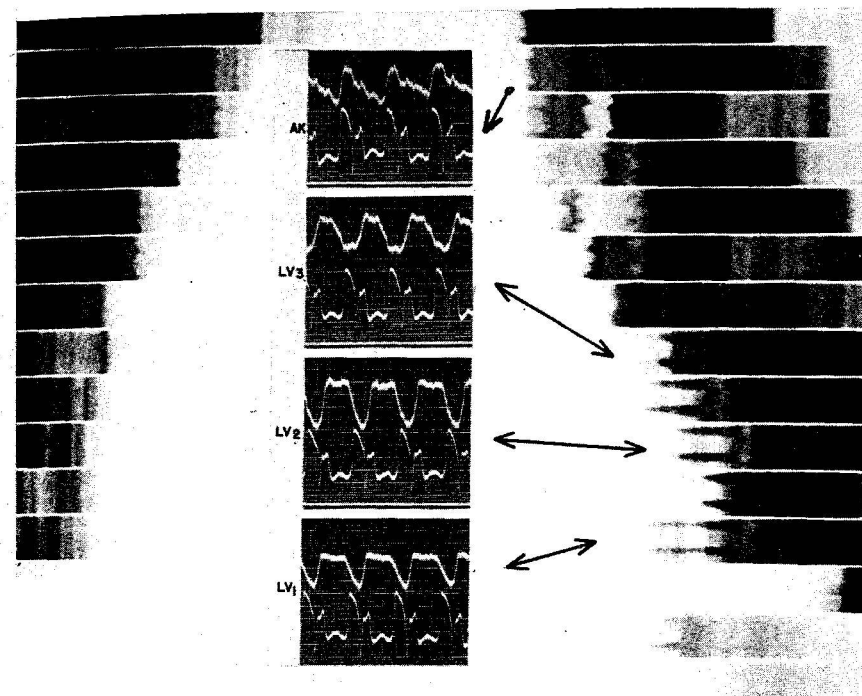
This patient, case 13 (1), had continuation of manifestations of constriction in spite of two cardiac decortications. Shown here are a roentgenkymogram and, superimposed on it for purposes of graphic visualization, some of the electrokymograms. In each "frame" of the roentgenkymogram border movement is read from bottom to top. The records show the over-shooting phenomenon at the end of rapid ventricular filling.
